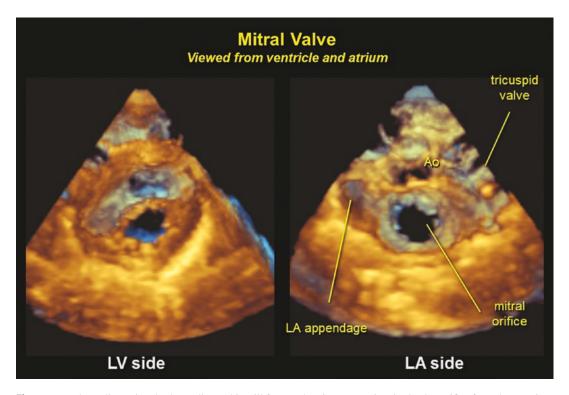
Three-dimensional echocardiographic still frames showing a stenotic mitral valve orifice from the ventricular (left) and atrial (right) perspectives. There is leaflet tip thickening and commissural fusion
